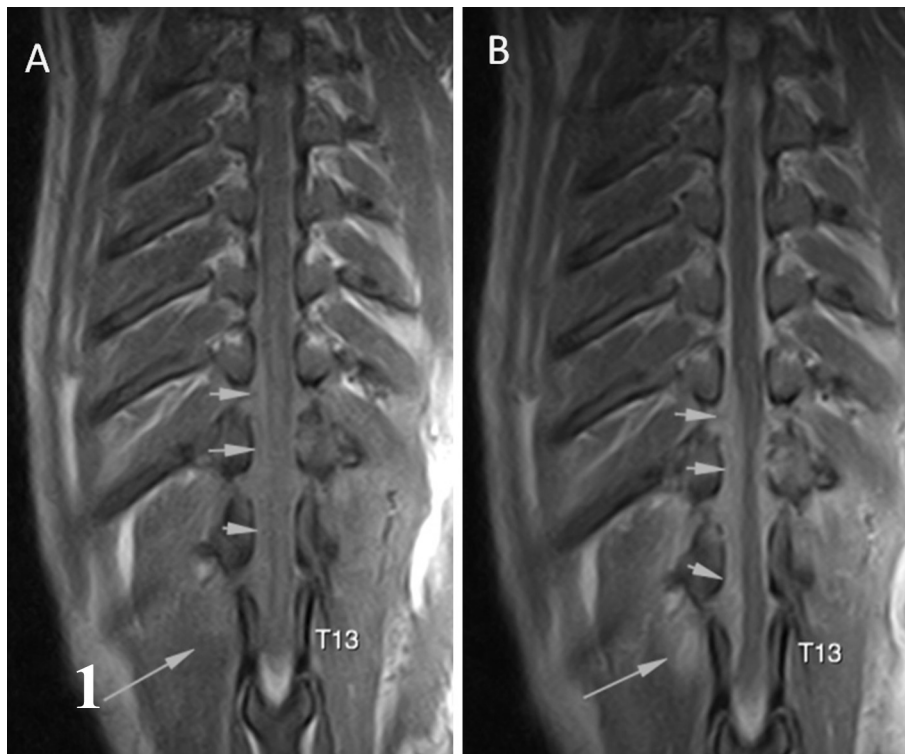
Magnetic resonance imaging. Dorsal T1-weighted (A) and T2-weighted (B) images show the isointense extradural lesion growing from T10 to T13 (arrowheads). Irregular intensity is also evident in paravertebral muscles (arrow).
